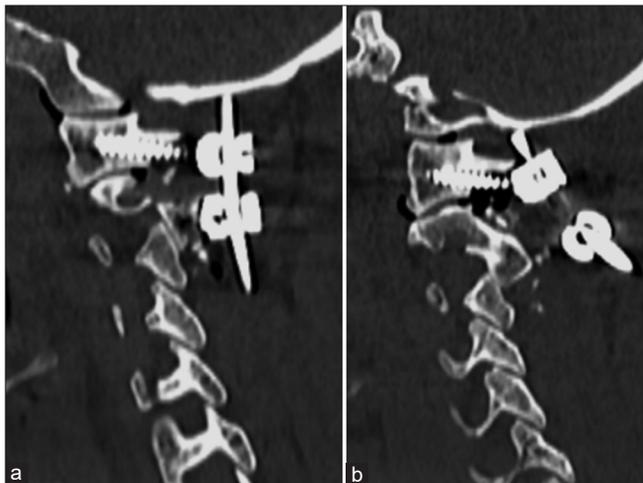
Sagittal CT scan showing the position of the screws within C1 vertebral body on the right (a) and left side (b), respectively.
